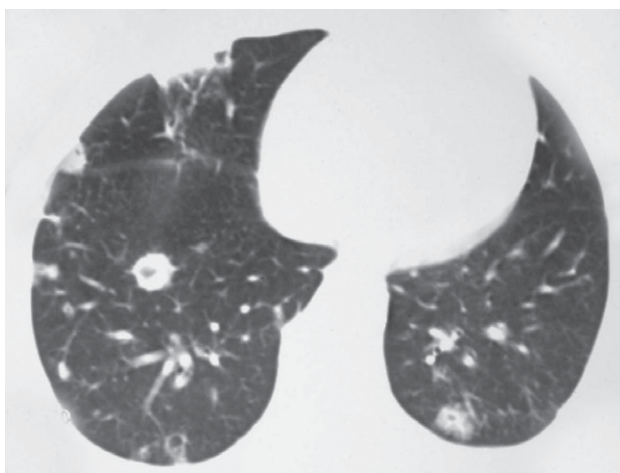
CT scan with lung window settings at the level of the lung bases, showing multiple nodules of various sizes, many of which were cavitated, with a predominant peripheral distribution.
